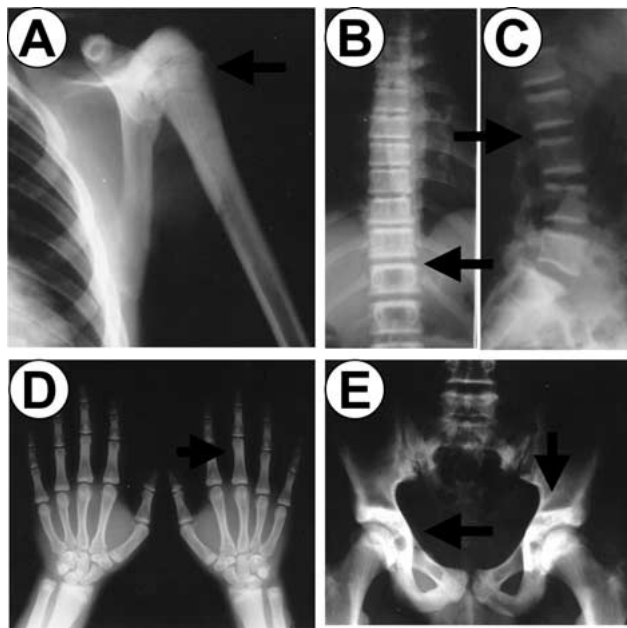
Radiographic analysis of the proband. (A) Humerus with sclerosis bands (arrow), (B) frontal and (C) lateral view of lumbar spine with “rugger-jersey” aspect (arrows), (D) hands’ phalange and (E) pelvis with “bone in bone” appearance (arrows).
